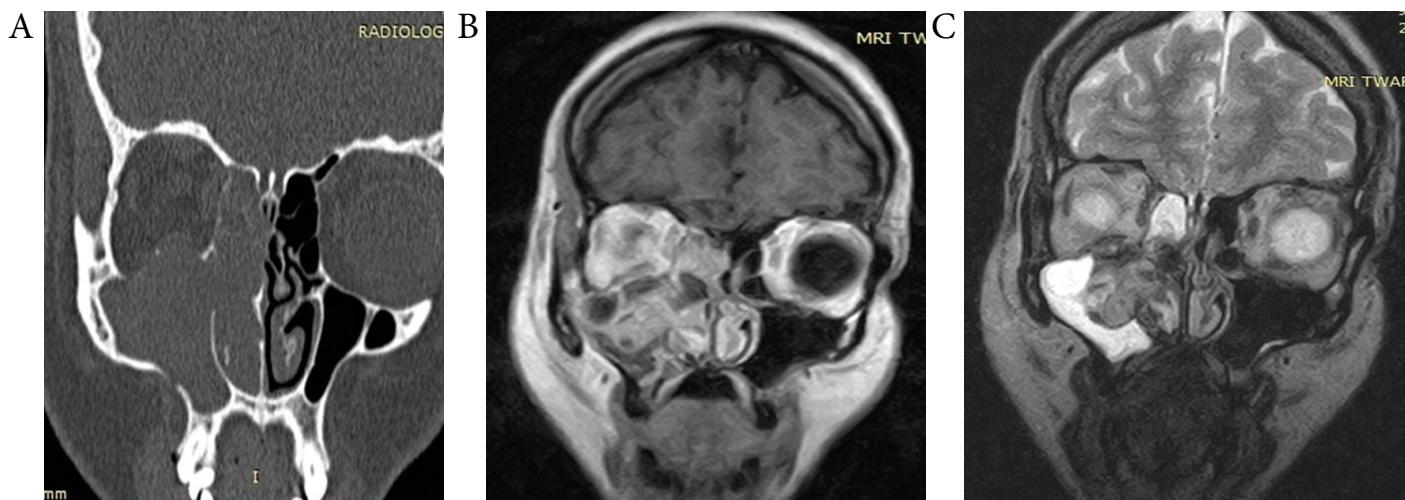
(A) CT and (B, C) MRI of Dąbska tumor in right maxillary sinus. CT and MRI images show penetration of the tumor masses into the orbit and the nasal cavity. MRI clearly shows the extent of tumor and the accompanying secondary changes in the sinuses.
